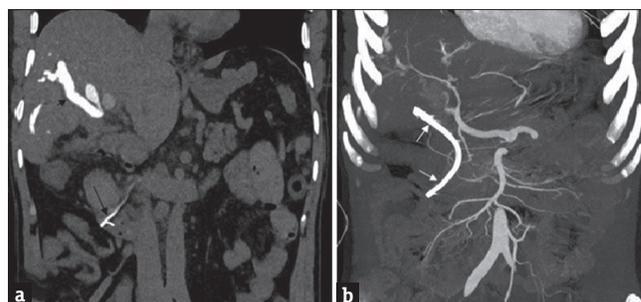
(a) Noncontrast computed tomography abdomen in coronal plane showing contrast filled dilated intrahepatic biliary radicles (small black arrow). The lower end of common bile duct stent (large black arrow) is also seen; (b) Coronal maximum intensity projection in arterial phase showing biliary stent (white arrow) away from hepatic artery branches with no active extravasation or pseudoaneurysm seen
